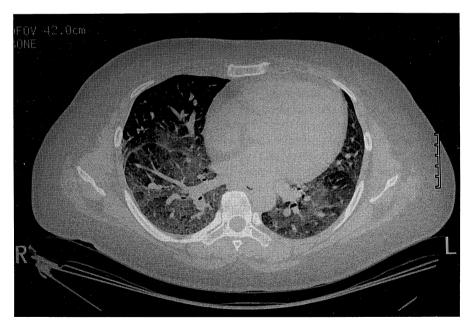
A chest CT scan on admission showing extensive ground-glass opacities and sparing in some regions in both lung fields.
